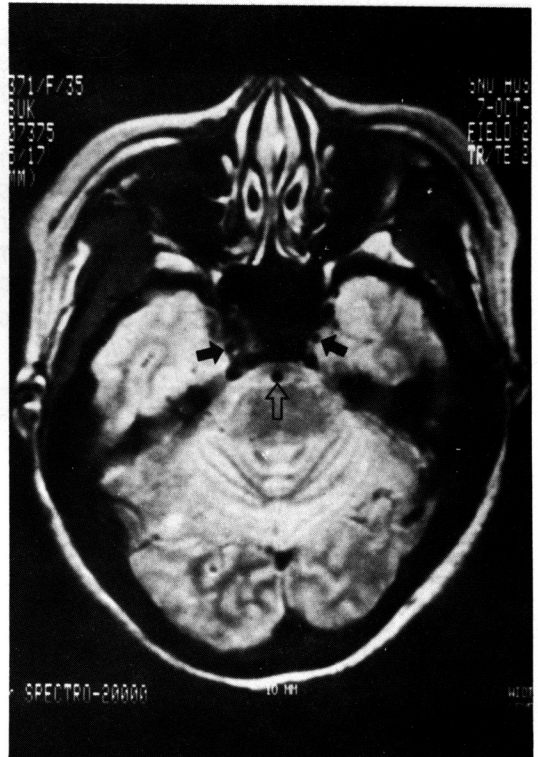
Axial MR image (SE 2500/30/1) of narrowing of cavernous internal carotid arteries. The cavernous portions of both internal carotid arteries (arrows) appear slightly smaller than the basilar artery (open arrow), suggesting narrowing of the artery.
